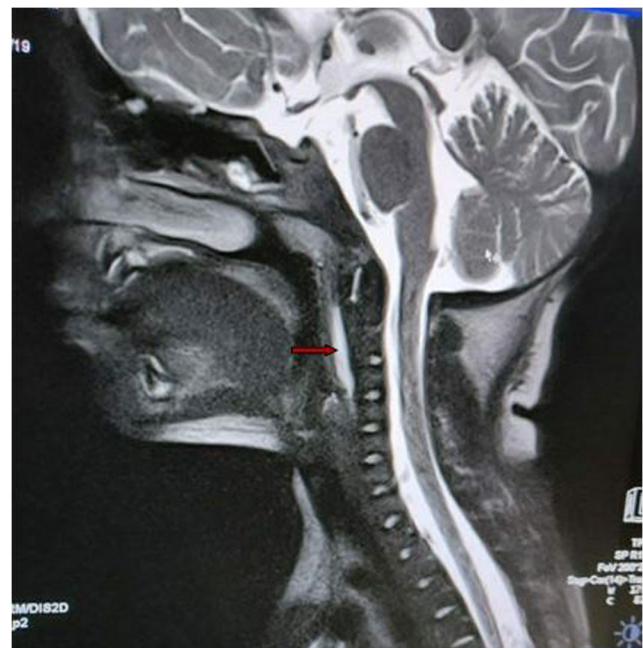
MRI neck showing linear retropharyngeal fluid collection with soft tissue edema without any compression over the airway
